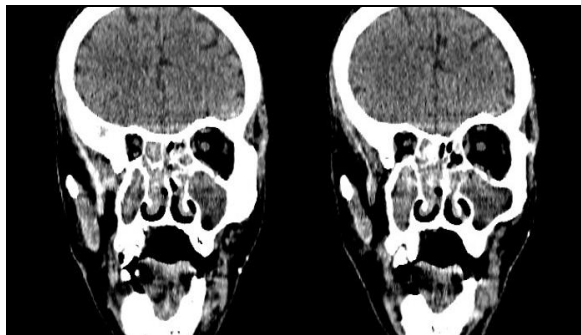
CT scan paranasal sinuses; coronal section; showing soft tissue density material in bilateral maxillary and ethmoidal sinuses
